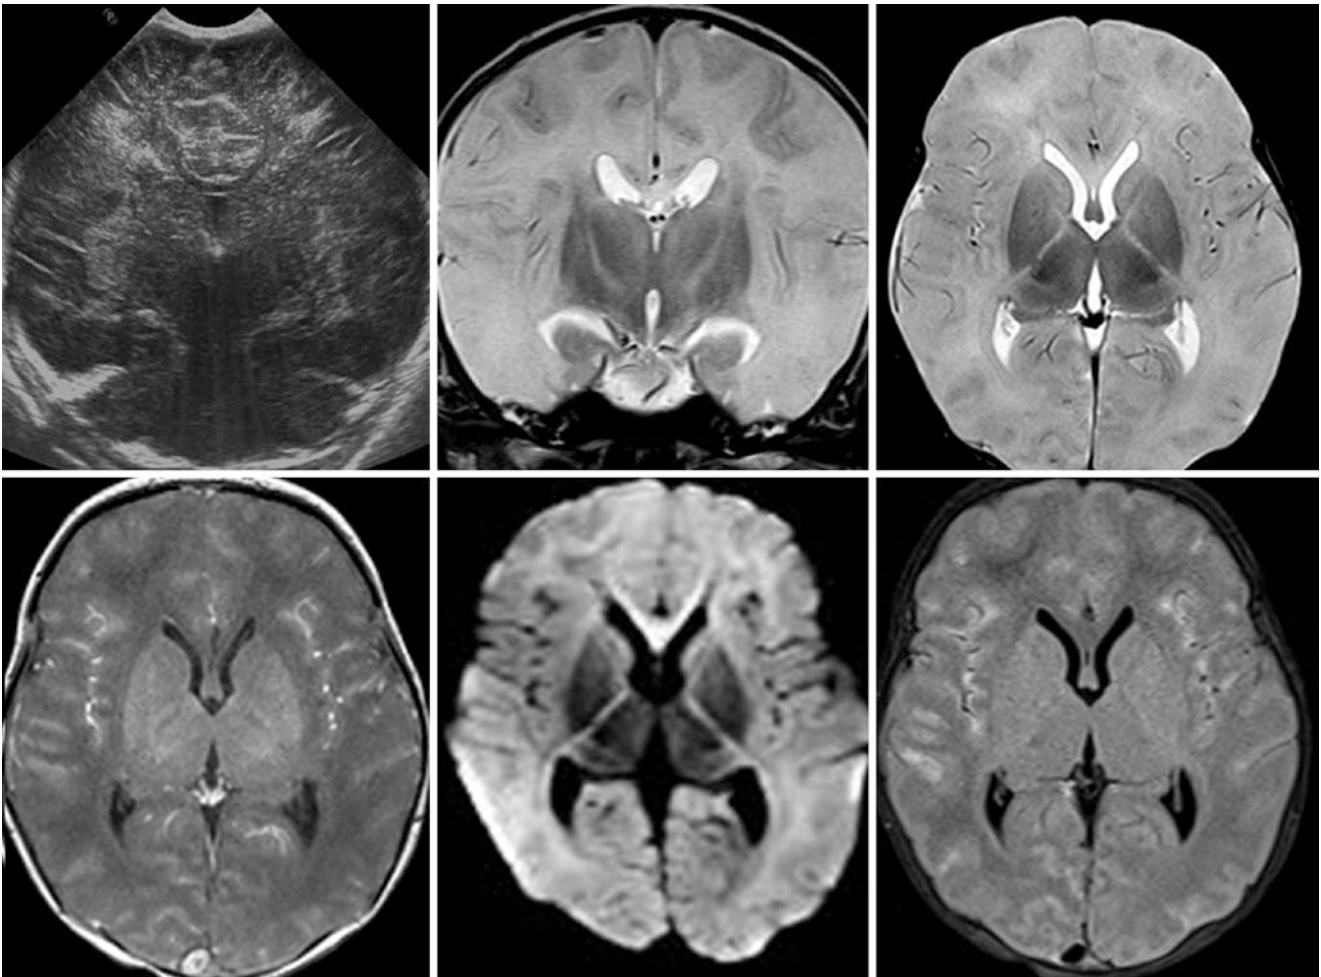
Comparison case of severe HII. *Top row:* A 3-day-old term neonate with respiratory failure had a coronal ultrasound (*left*) that noted cerebral edema. 3T MRI demonstrated diffuse, severe edema with loss of the sulci and of the normal, T2-dark cortical “ribbon,” as shown on coronal (*middle*) and axial (*right*) SE T2WIs. *Bottom row:*
